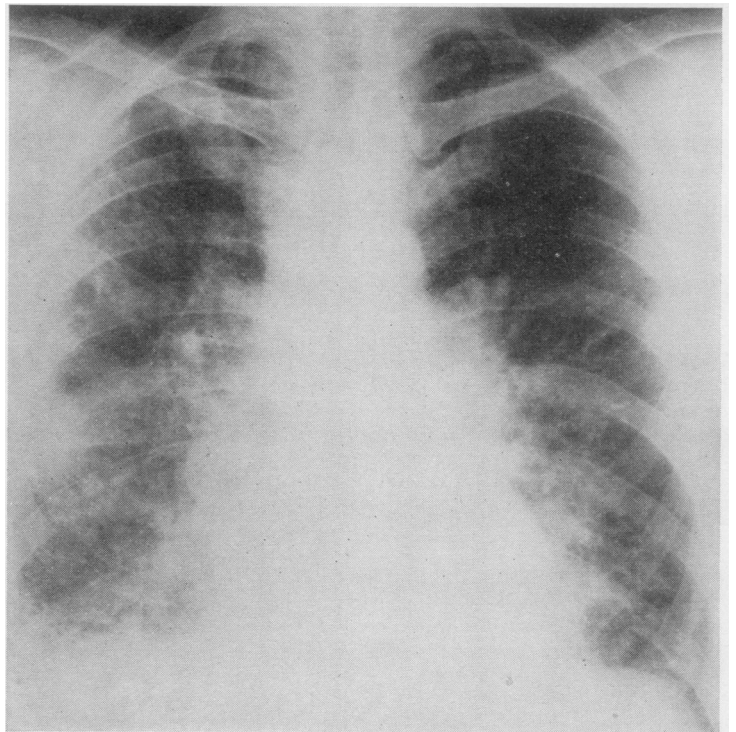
Radiograph of the chest of patient S.M., showing extensive mottling with 'honeycomb' appearances. A radiograph six years earlier had shown fine generalized mottling without honeycombing.
